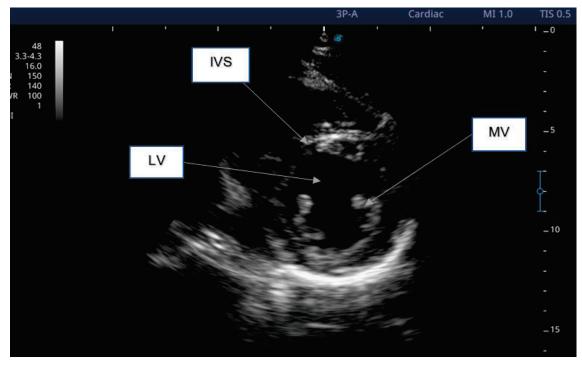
Parasternal short-axis view demonstrating LV, MV, IVS
